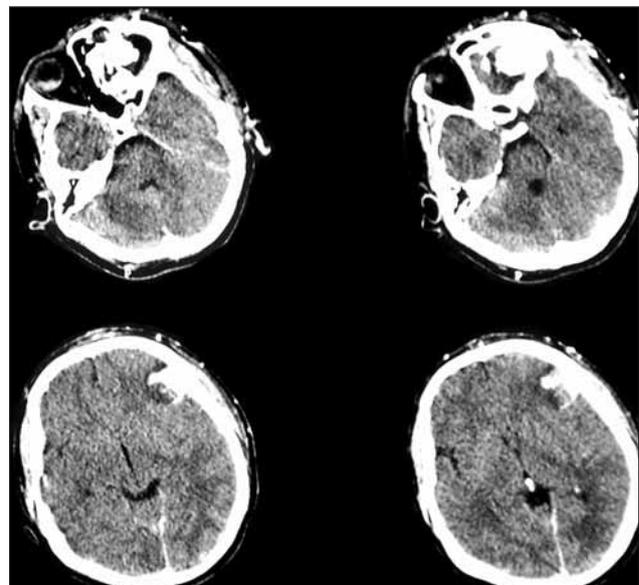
Four slices CT scan of a patient with left orbitocranial injury caused by landmine explosion. A foreign body in the left orbit and hemorrhage in the left frontal lobe are obvious.
